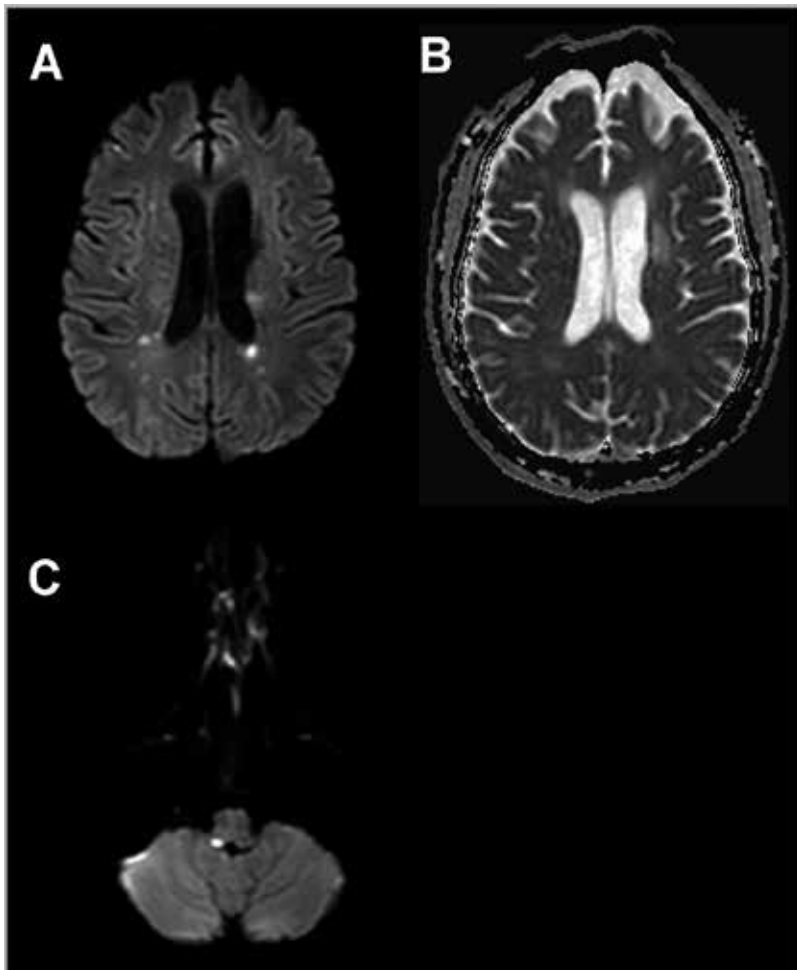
Magnetic resonance imaging (MRI) in two cases of asymptomatic and symptomatic cerebral infarction related to catheterization. (A) Diffusion-weighted MR image of Case 1. (B) Apparent diffusion coefficient (ADC) map of Case 1. (C) DW-MR image of Case 2.
